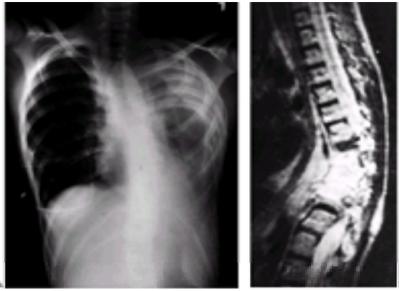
Twelve-year-old male with Gorham disease. A: Chest x-ray demonstrates loss of ribs 8, 9, and 10, and a chylothorax. B: The neovascular tissue is bright on T2 and on this MRI, there is extensive vertebral destruction and paravertebral involvement. This boy died from this process.
